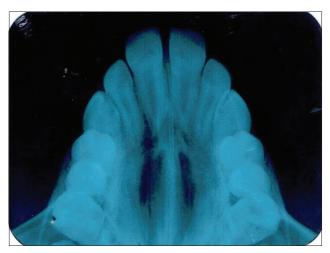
Occlusal radiograph maxillary arch
